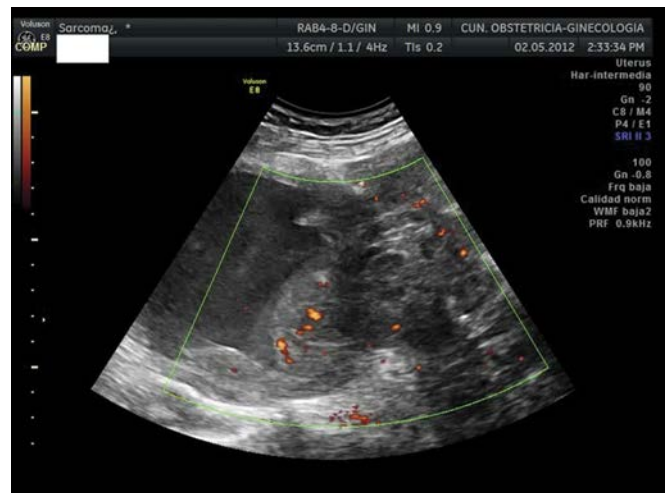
Transabdominal ultrasound showing a pelvic mass with cystic areas and moderate vascularization. Contours are irregular. The uterus cannot be recognized. A uterine sarcoma was suspected and confirmed after hysterectomy.
